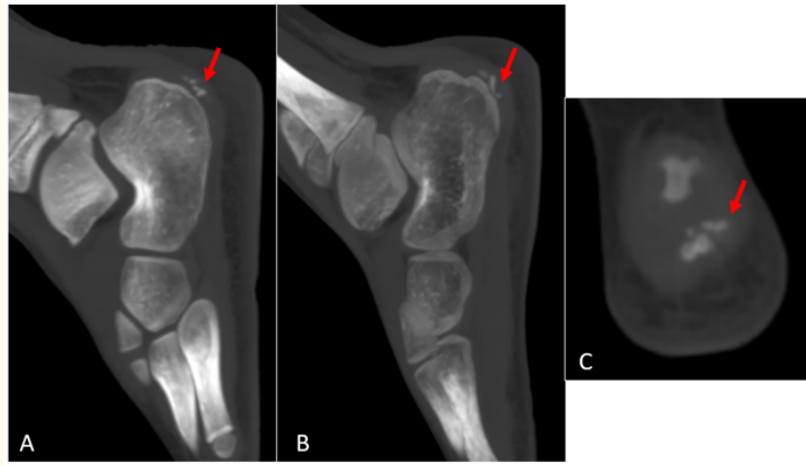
Sagittal (A, B) and coronal (C) CT images of the right calcaneus demonstrate irregular fragmentation of the secondary ossification center of the posterior calcaneal apophysis (Red arrows), associated with reactive sclerosis of the adjacent calcaneal metaphysis and inflammatory infiltration with partial effacement of the pre-Achilles (Kager's) fat pad. No cortical destruction, fracture line, periosteal reaction, or focal osteolytic lesion is identified. These findings are consistent with calcaneal apophysitis (Sever's disease).
